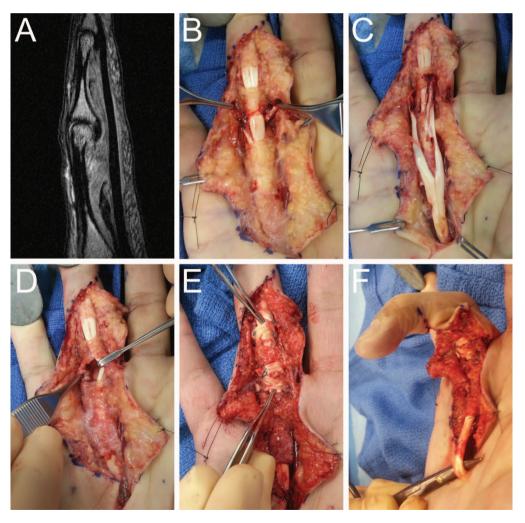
(A) MRI of the ring finger showing disruption of the FDS tendon in zone II and palmar displacement of the FDP consistent with pulley disruption. (B) Intra-operative photograph showing ruptured FDS tendon in zone II with A2, A3, and A4 pulley ruptures. (C) FDS tendon placed superficial to the flexor pulley apparatus and harvested. (D) FDP tendon retracted to demonstrate the remaining rim. (E) After pulley reconstruction. (F) Demonstration of the absence of bowstringing with FDP retraction.
